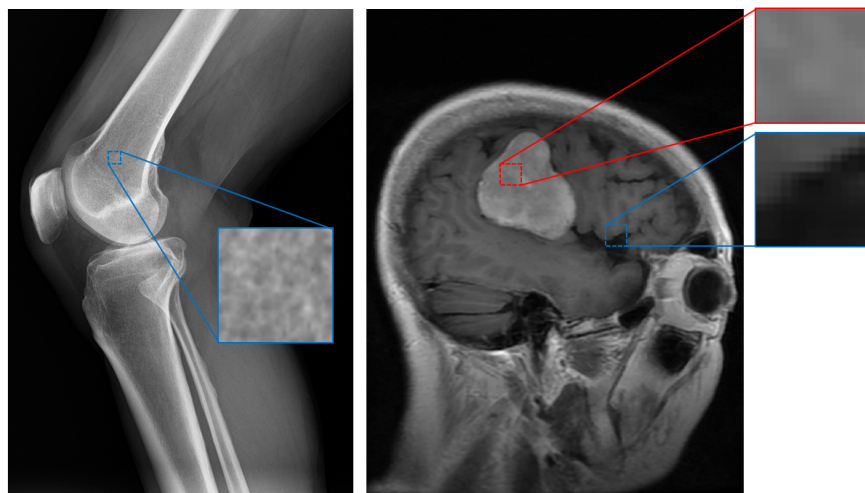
Sample texture patches from a knee X-ray and brain MRI.
